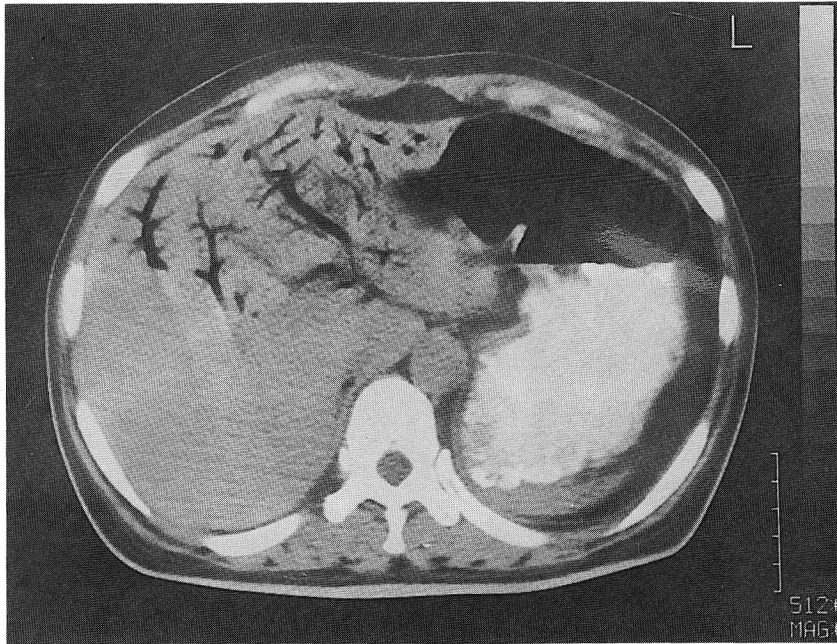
CT scan of the liver reveals hepatic portal venous gas which was extended to almost periphery of the liver edge.
